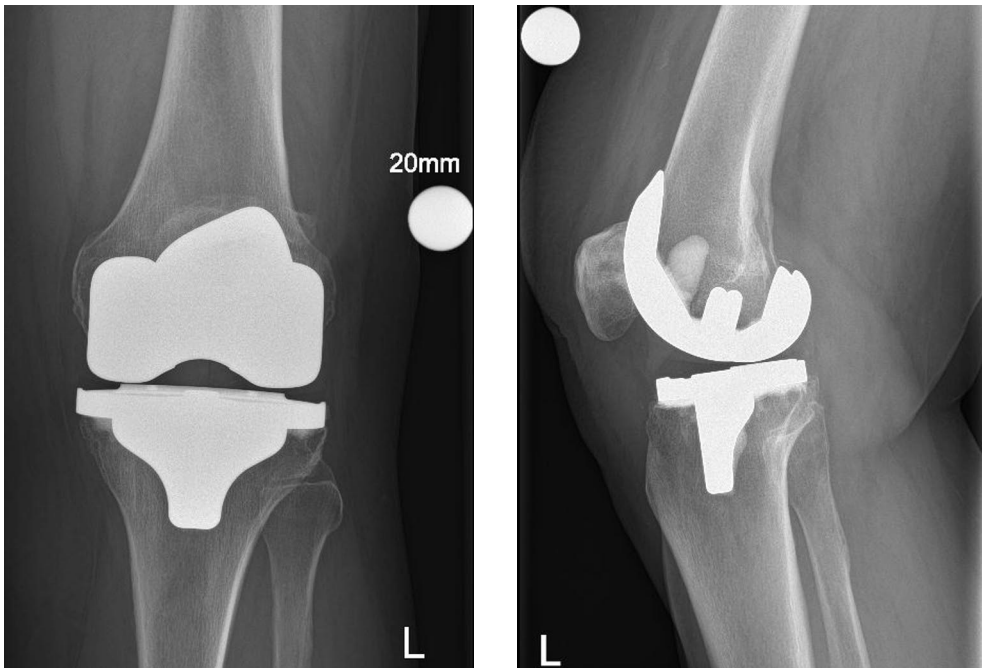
Radiographs of total knee arthroplasty in a 59-year-old woman 2 years after surgery.
